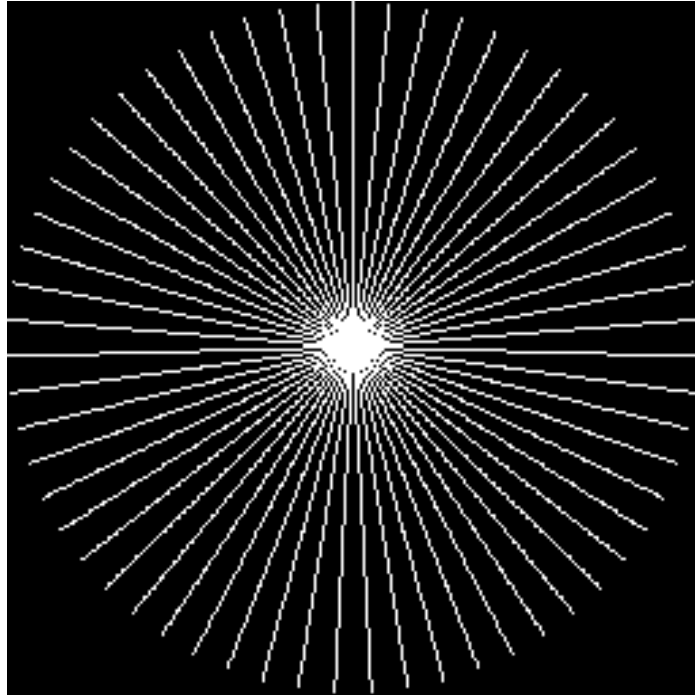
Sparse-view CT whose sampling consists of 59 projections that are evenly spaced out thorough the entire circle.
